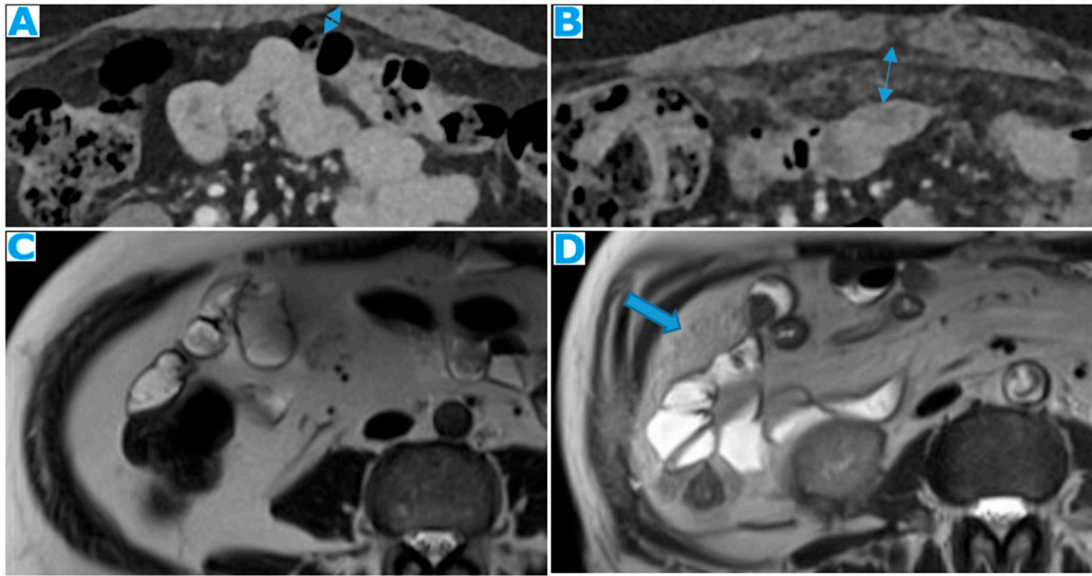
Axial CE-CT (A from one-year prior, B current follow up). PC from breast carcinoma: Note the omental infiltration on B associated with a posterior displacement of the small bowel loops. Axial T2WI (C peritoneal-disease-free study from two years prior, D current follow up). PC from renal cell carcinoma: Enlargement of the fatty content and mass effect due to omental seeding (arrow) that may be more conspicuous than the actual deposits.
